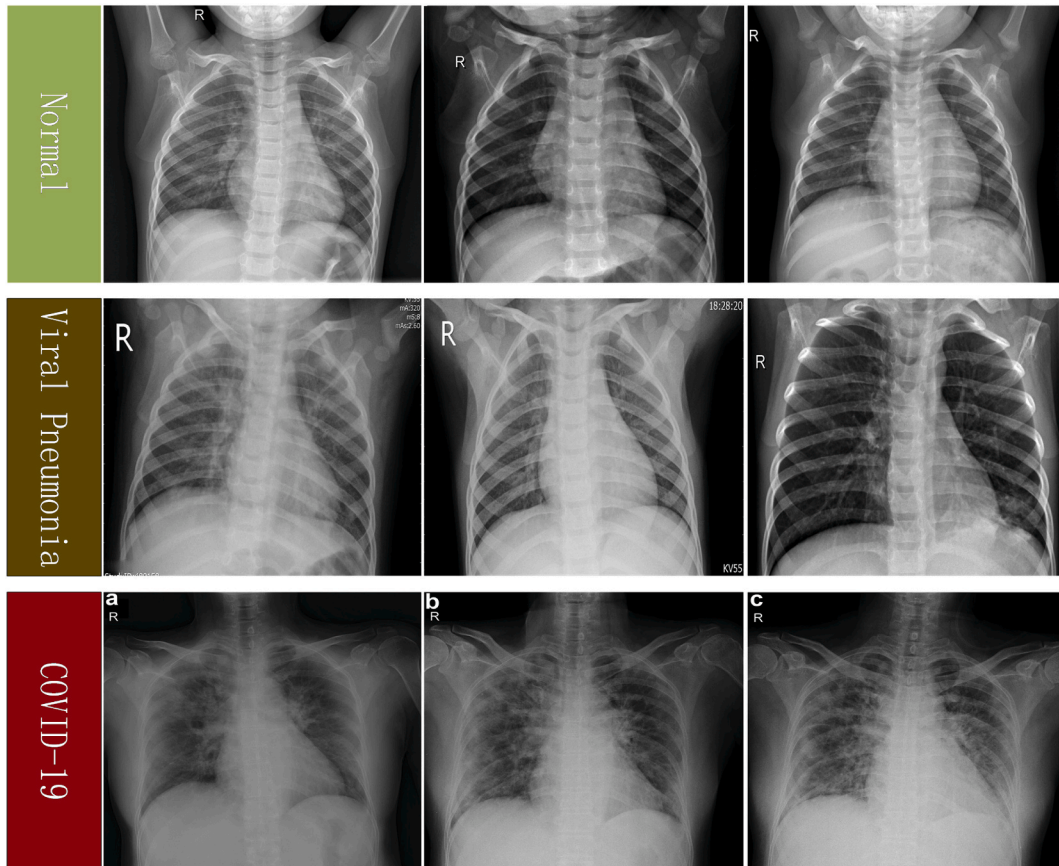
Example of chest X-ray images in Kaggle’s COVID-19 Radiography Dataset: (first row) Normal chest X-ray images, (second row) Viral Pneumonia chest X-ray images, (third row) COVID-19 chest X-ray images.
